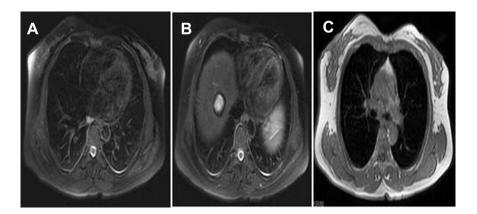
Baseline MRI: (A) Malignant mass in the inner quadrant of left breast; (B) Multiple mixed hyperintense necrotic, non-necrotic lesions in liver; (C) Pulmonary nodules with restricted diffusion in lung.
